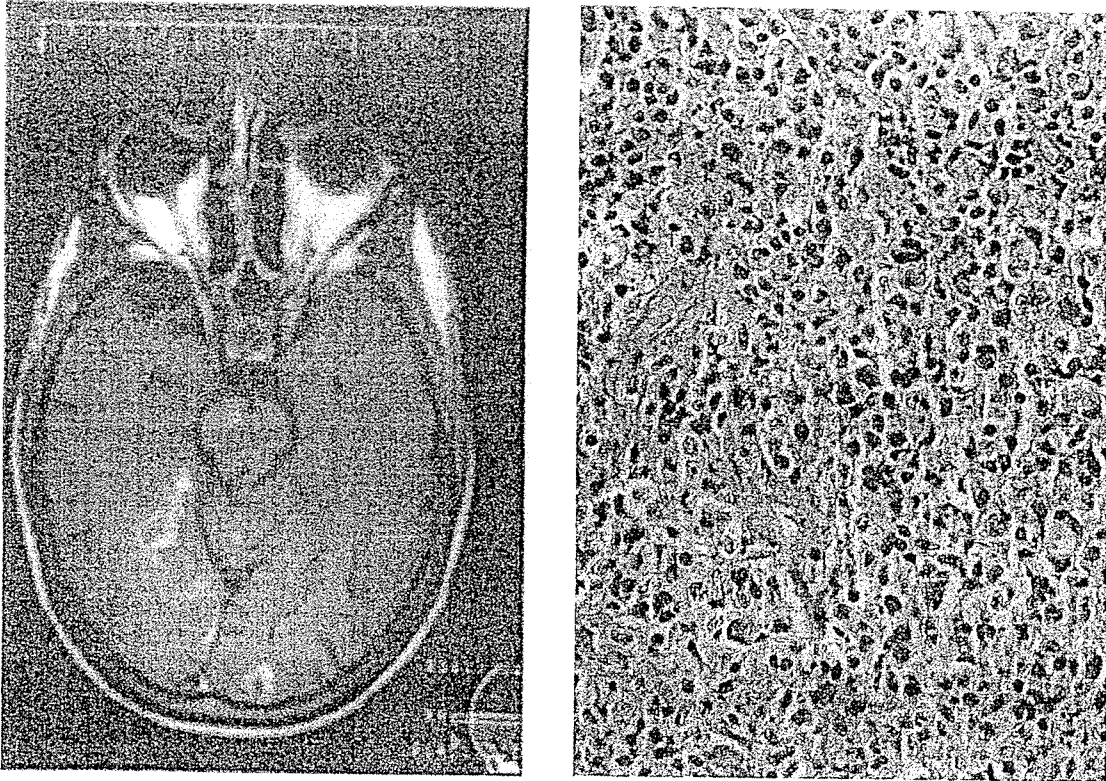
Patient with toxoplasmosis of the brain on prolonged therapy with an alternating regimen of AZT and ddC who subsequently developed primary central nervous system lymphoma. The patient's toxoplasmosis initially responded to therapy with pyrimethamine and sulfa. However, this neurologic symptoms subsequently worsened, and magnetic resonance imaging showed new lesions (left). Biopsy of the brain at this time showed a small non-cleaved cell lymphoma (right).
